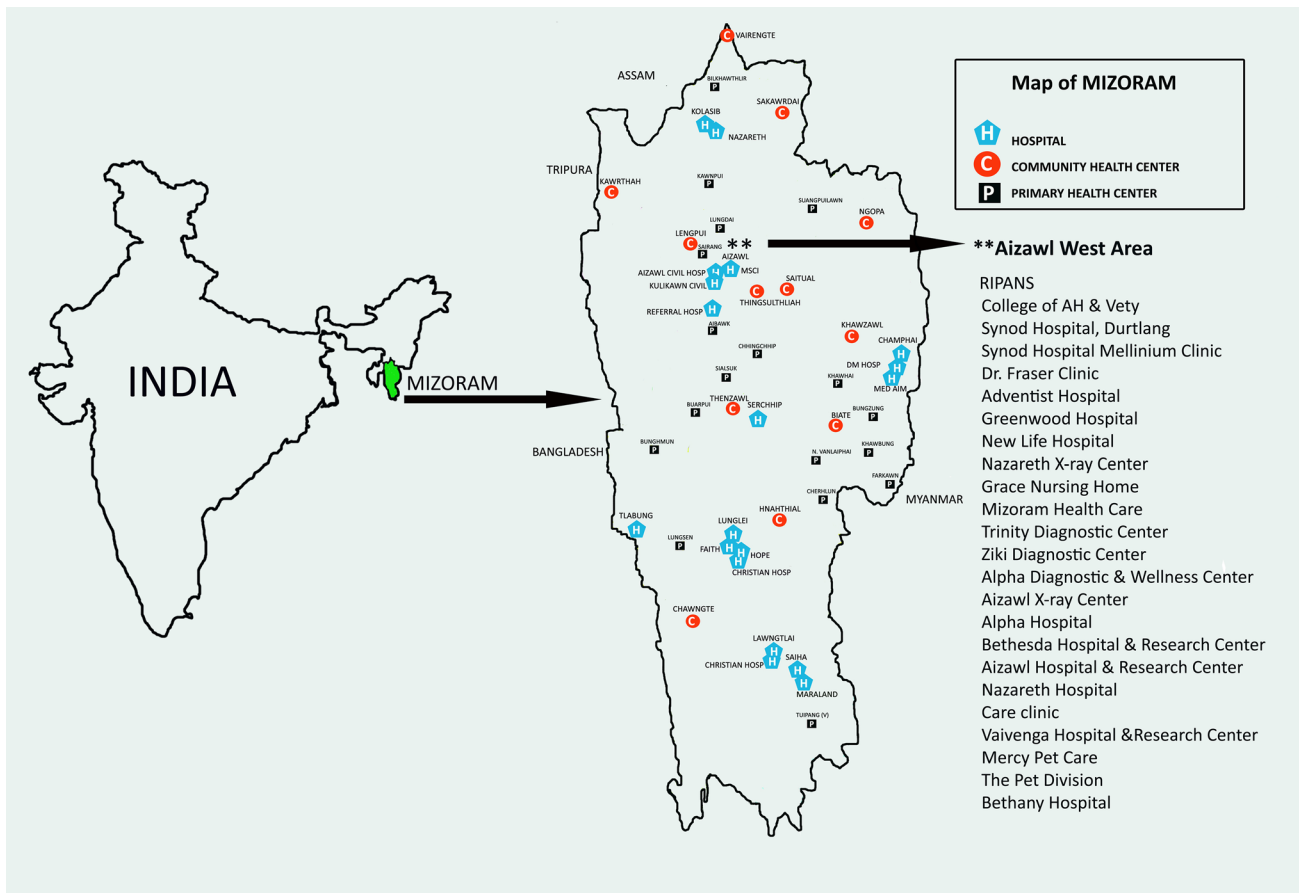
Locations of the diagnostic X-ray machines included in this study
